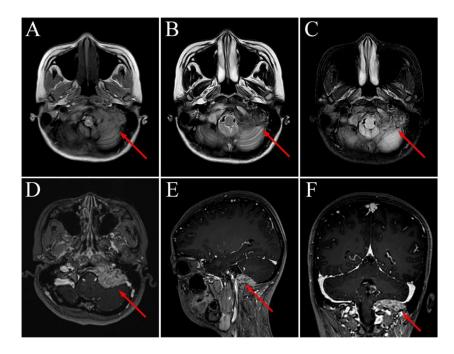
Preoperative MRI findings from 1 week prior. T1WI, T2WI and T2 fat suppression sequences (A-C); T1WI enhancement (D-F).
